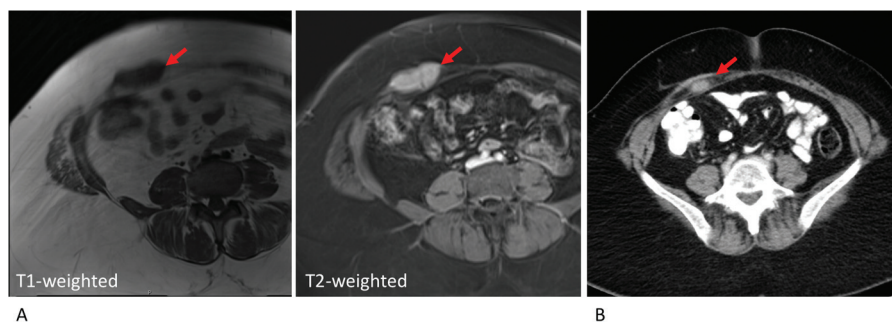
Pre-operative radiographic studies of port-site metastasis. A: Magnetic resonance imaging of abdomen and pelvis with and without intravenous contrast in 2016. T1- and T2-Weighted axial images demonstrating diffusely enhancing mass measuring 2.0 × 4.1 × 3.1 centimeters, involving the right rectus sheath. B: computed tomography of abdomen and pelvic with intravenous contrast and oral contrast showing 1.7 centimeter right abdominal wall metastatic implant.
